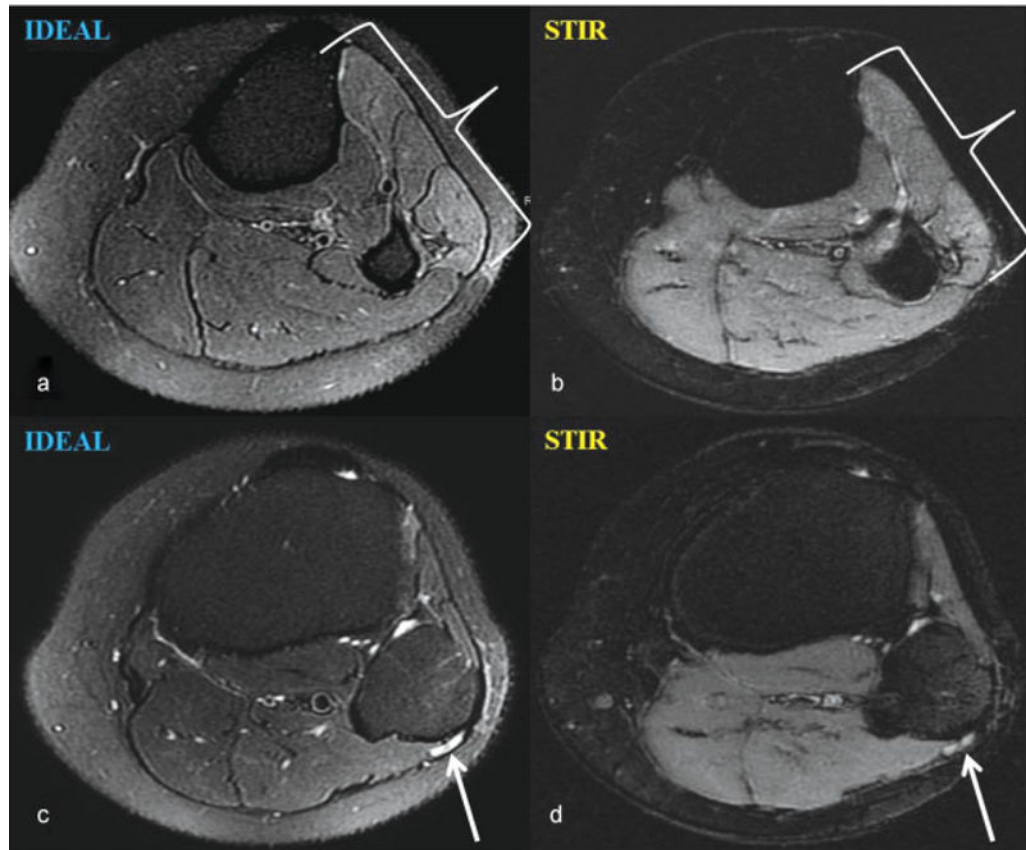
Axial T2-weighted iterative decomposition of water and fat with echo asymmetry and least-squares estimation (IDEAL) image performed on a 3.0-T magnet demonstrates (a) a denervation edema pattern within the anterior and lateral leg muscle compartments that cannot be confidently appreciated on the corresponding short tau inversion recovery (STIR) image (b). Signal hyperintensity of the common peroneal nerve as it courses around the fibular head is also more conspicuous on IDEAL (c) compared with STIR (d) imaging.
